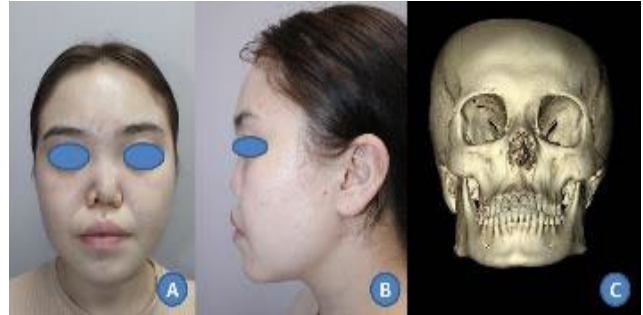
Preoperative photographs and computed tomography demonstrating nasal deformity with anterior nasal spine defect secondary to neonatal nasal tube-related infection
